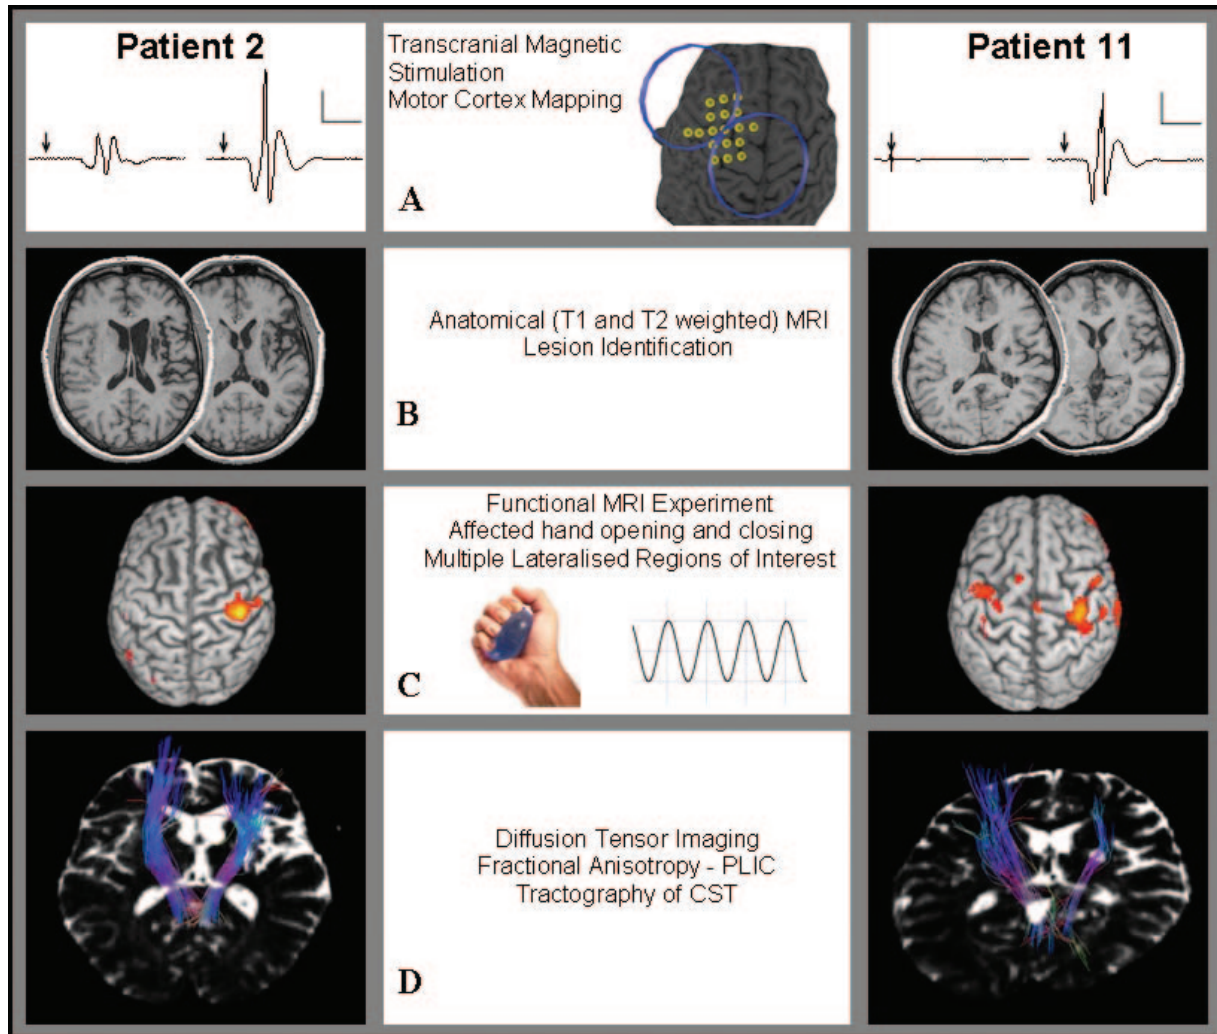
Functional and structural data from Patients 2 and 11. FM upper limb scores: Patient 2 = 23; Patient 11 = 9. (A) For each pair of traces, the affected ECR is presented on the left, and unaffected ECR on the right. TMS elicited MEPs in the affected upper limb of Patient 2, but not Patient 11. Arrows indicate time of magnetic stimulus. Calibration bars: 0.2 mV and 25 ms. (B) Both patients had a right hemisphere stroke. (C) During affected hand use functional MRI revealed ipsilesional cortical activity for Patient 2, and bilateral cortical activity for Patient 11. Patients squeezed and released saline bags connected to pressure transducers, which allowed monitoring of behavioural performance. (D) Superior–posterior view of an axial T₂ image, overlaid at the level of the PLIC by CST fibres. The CST fibres depicted are those that originate in the hand area of the precentral gyrus. Diffusion tensor imaging was used to calculate FA in the PLIC. The FA asymmetry values were 0.21 for Patient 2, and 0.15 for Patient 11. Both patients had improvements in FM scores of 4 points, following one month of motor practice with the affected upper limb.
